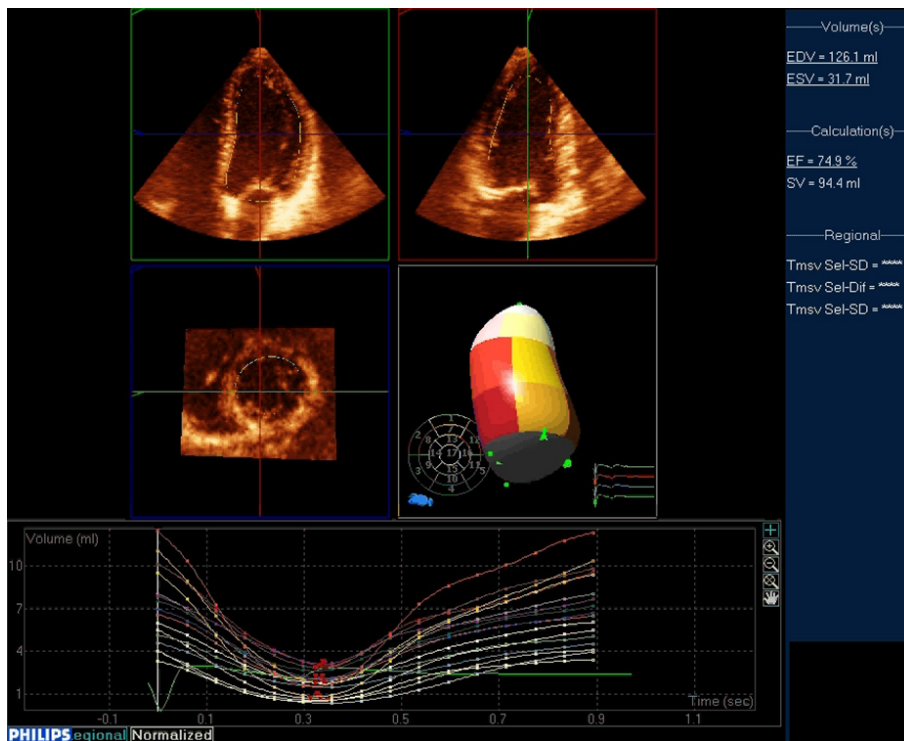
Real-time three-dimensional transthoracic image demonstrating the left ventricular end-diastolic volume (EDV), left ventricular end-systolic volume (ESV), and the curves for derivation of left ventricular regional dyssynchrony indexes in a normal individual.
